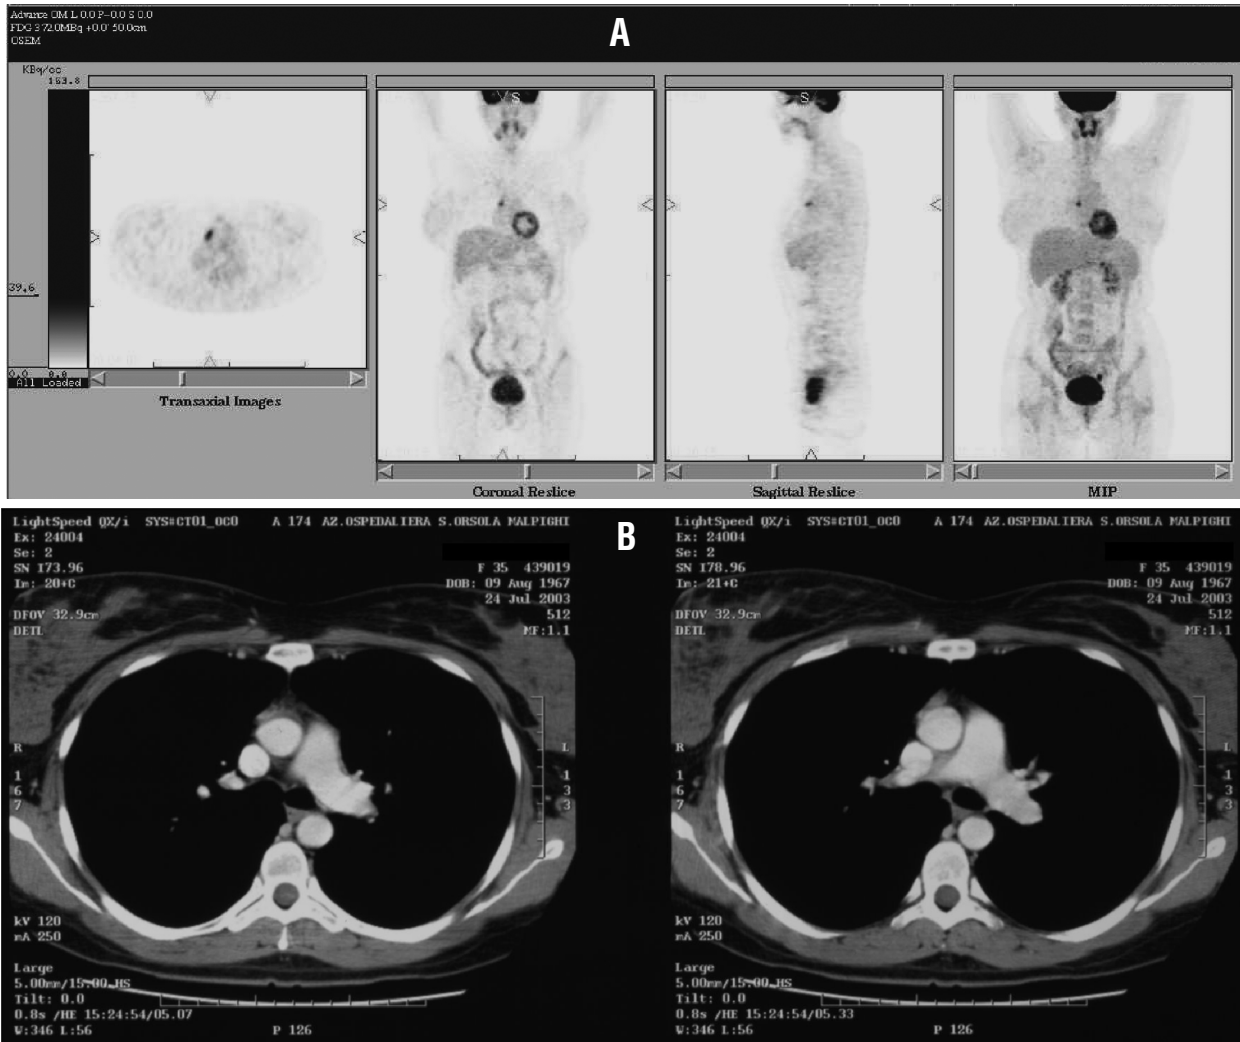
FDG PET showing an area of increased uptake in the mediastinum (A). The corresponding CT (after 7 days) was reported as negative for active disease (B).
